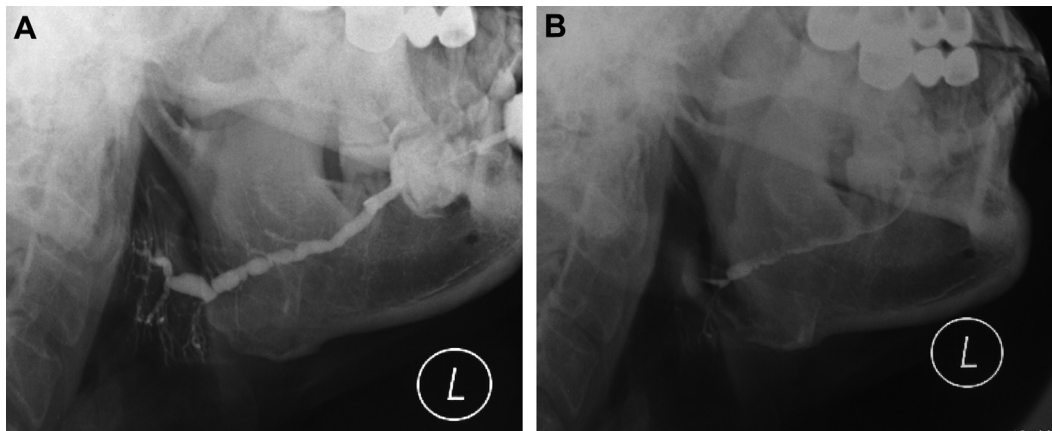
A 50-year-old man with a 10-year history of sialoliths in the left parotid gland. The stones were removed using method 2. This patient had occasional swelling of the affected gland. A, Follow-up sialography at 8 months showed sausage-like appearance of the main duct. B, Persistent contrast was evident on the functional radiograph.
